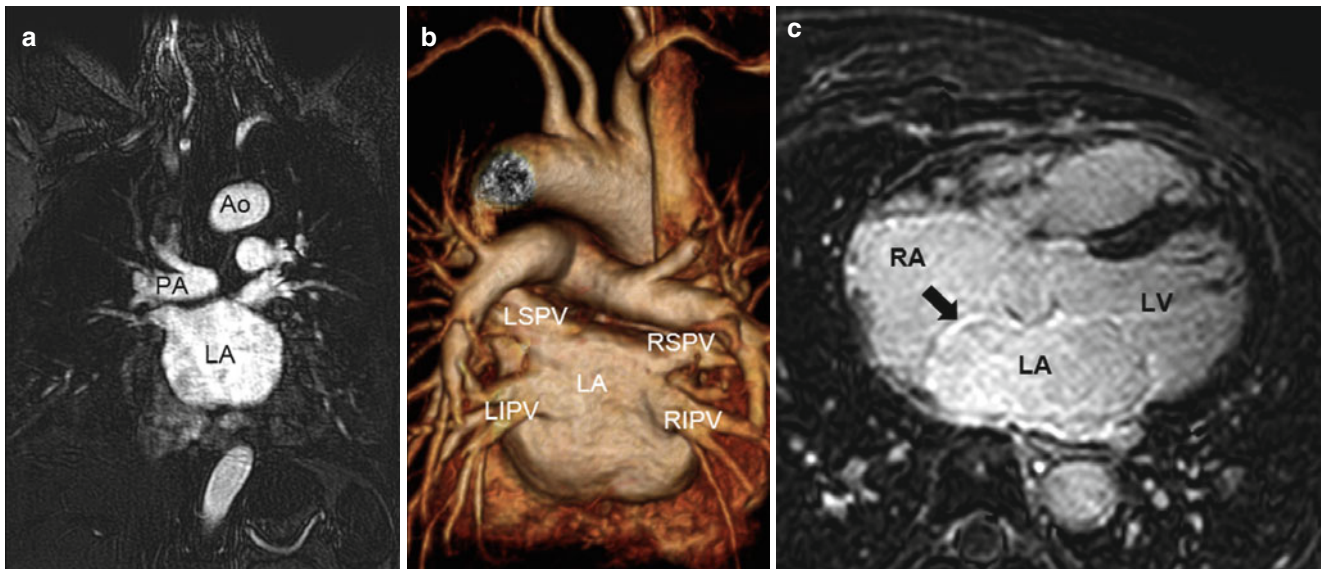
Cardiac MR images to prepare the catheter ablation of atrial fibrillation. In the basis of three-dimensional time-resolved contrast-enhanced MR angiography (a), the volume-rendered MR image (b) provides the virtual appearance of the left atrium and pulmonary vein for the “roadmap” in the catheter ablation. Sequentially, late-gadolinium enhancement MR
